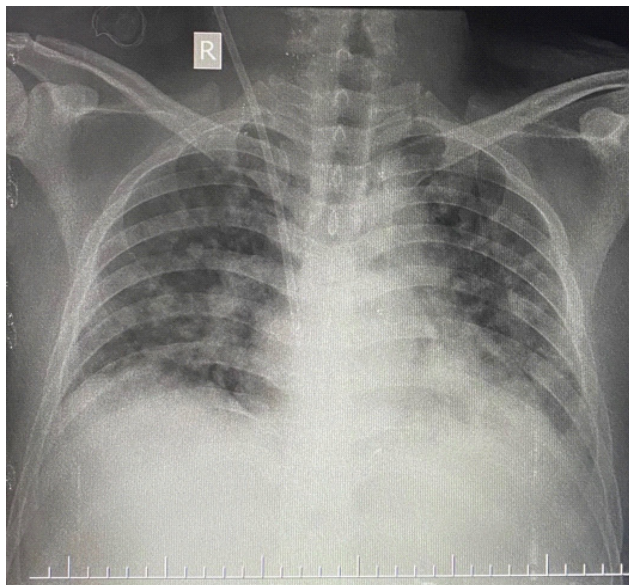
Radiograph of patient in Day 11.
